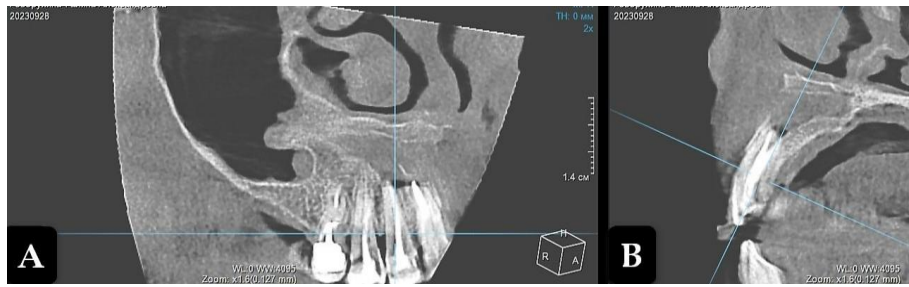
Cone-beam computed tomography. Residual bone cavity 1 year after enucleation of radicular cyst (projection of tooth 12). A: Frontal projection; B: Sagittal projection.
